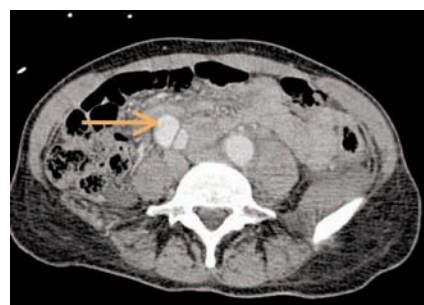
Axillary computed tomography scan shows the expansion of the dissection to the iliac artery.
